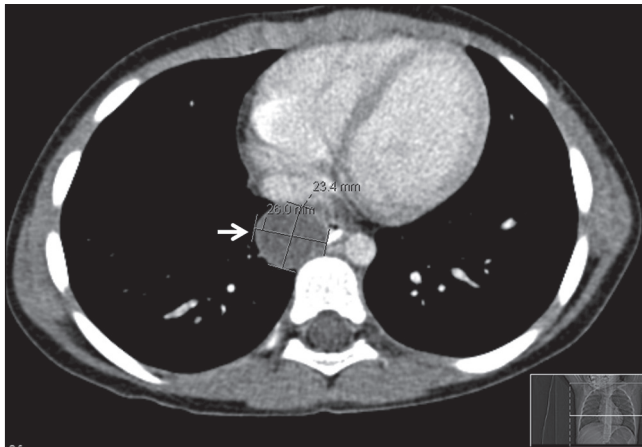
Computed Tomography showing a right posterior mediastinal cyst adjacent to the oesophagus (white arrow) (original)
